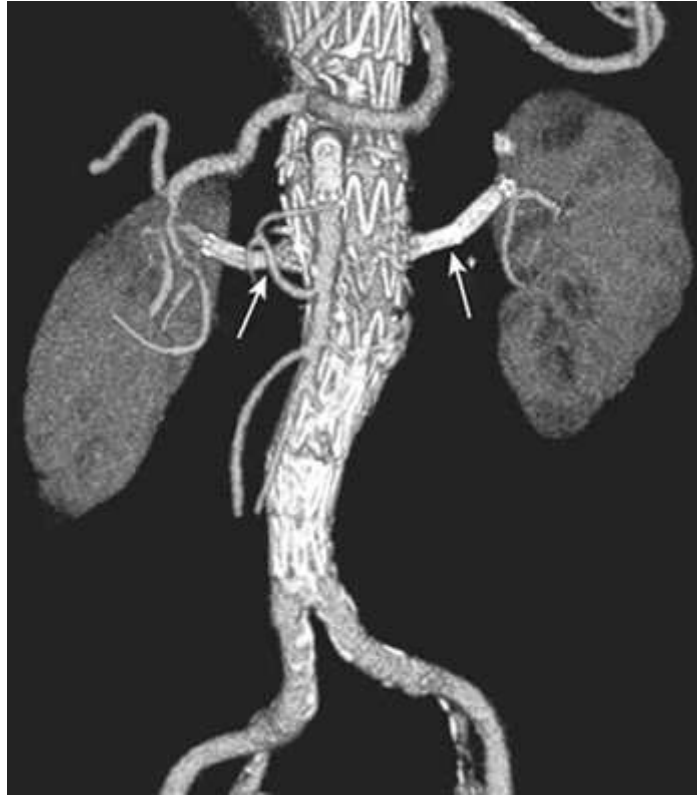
Fenestrated, or branched, endograft. Volume rendering of a computed tomographic angiography showing a fenestrated endograft (Zenith, Cook, Bloomington, IL). There are extensions into both renal arteries (*arrows*), the superior mesenteric artery, and celiac artery. From Kaufman JA: Abdominal aorta and pelvic arteries. In Kaufman JA, Lee MJ, editors: *Vascular and interventional radiology: the requisites*, ed 2, Philadelphia, 2014, Elsevier. Courtesy Roy Greenberg, MD, Cleveland, OH.
